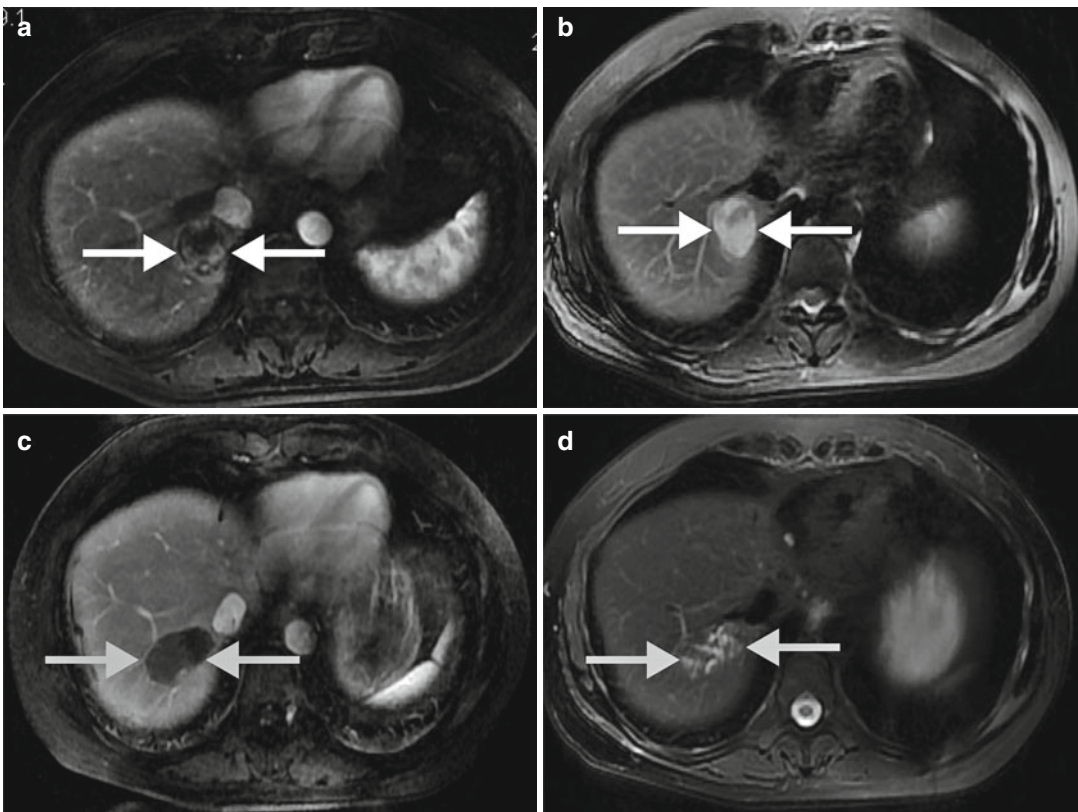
A 51-year-old woman with liver metastasis from retroperitoneal leiomyosarcoma treated with microwave ablation (MWA). (a, b) Preablation-enhanced magnetic resonance imaging (MRI) shows the lesion (3.3 cm × 3.2 cm) adjacent to the inferior vena cava (white arrow); (c, d) 6 months after MWA, enhanced MRI shows no residual tumour in the ablation zone (grey arrow); (e, f)
